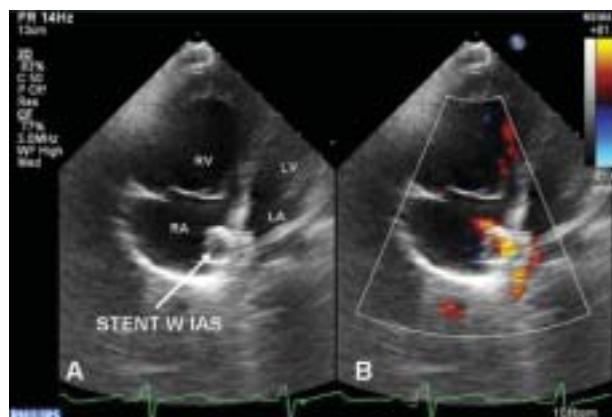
Transthoracic echocardiography, modified apical 4-chamber view. A stent can be seen within the interatrial septum (IAS); A. Two-dimensional image; B. Colour Doppler imaging of the flow through the implanted stent. For abbreviations see Figure 2
